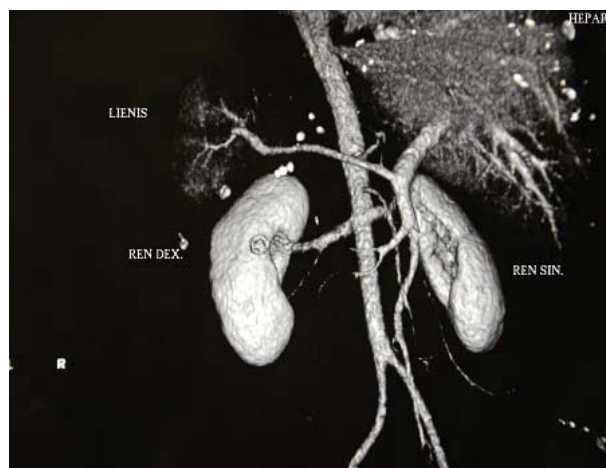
Donor's multislice computed tomography with angiography.
